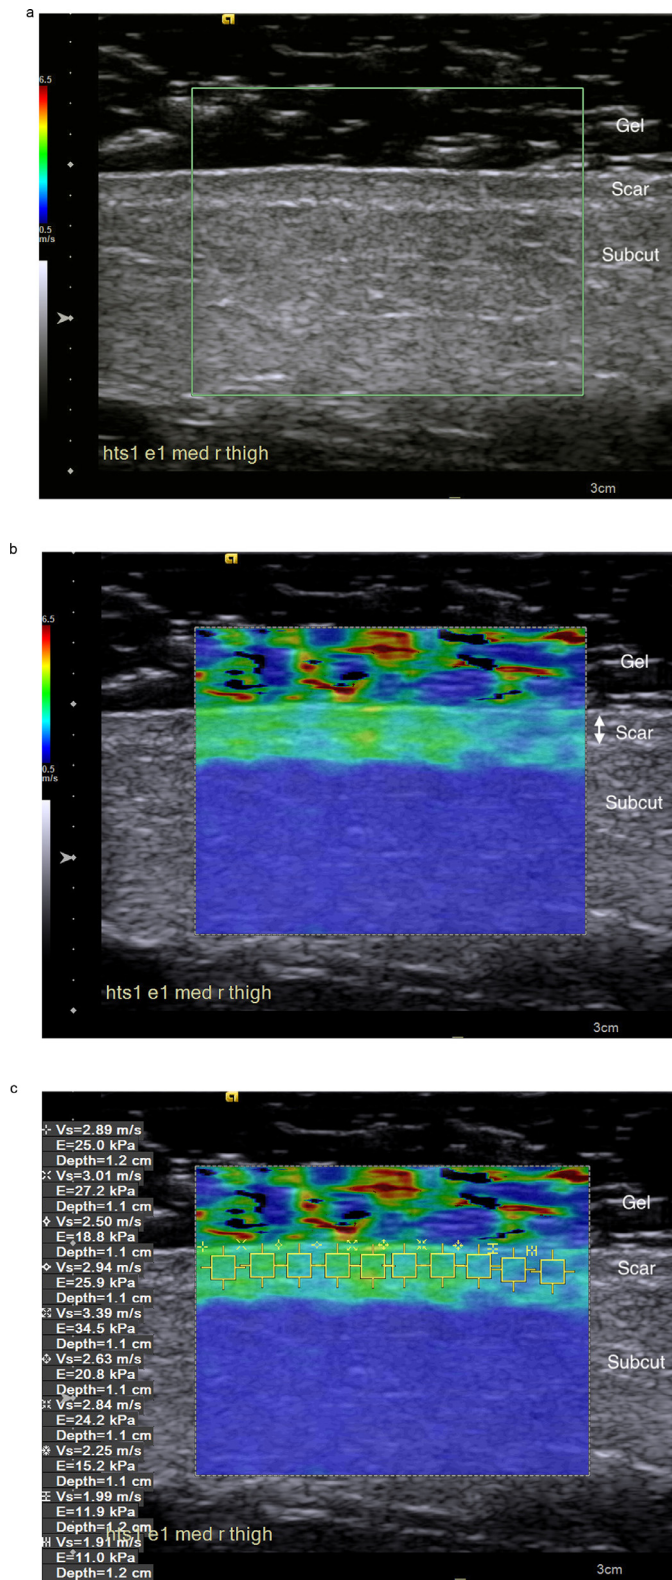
Shear wave elastography. (a) Ultrasound image of a 12-mo-old scar resulting from a deep partial-thickness flame burn on the thigh of a 57-y-old man. The scar was flat and had a Vancouver Scar Scale Pliability score of 2. (b) Associated elastogram. (c) Associated elastogram with 10 sampling boxes positioned to capture the shear wave speed of the scar.
